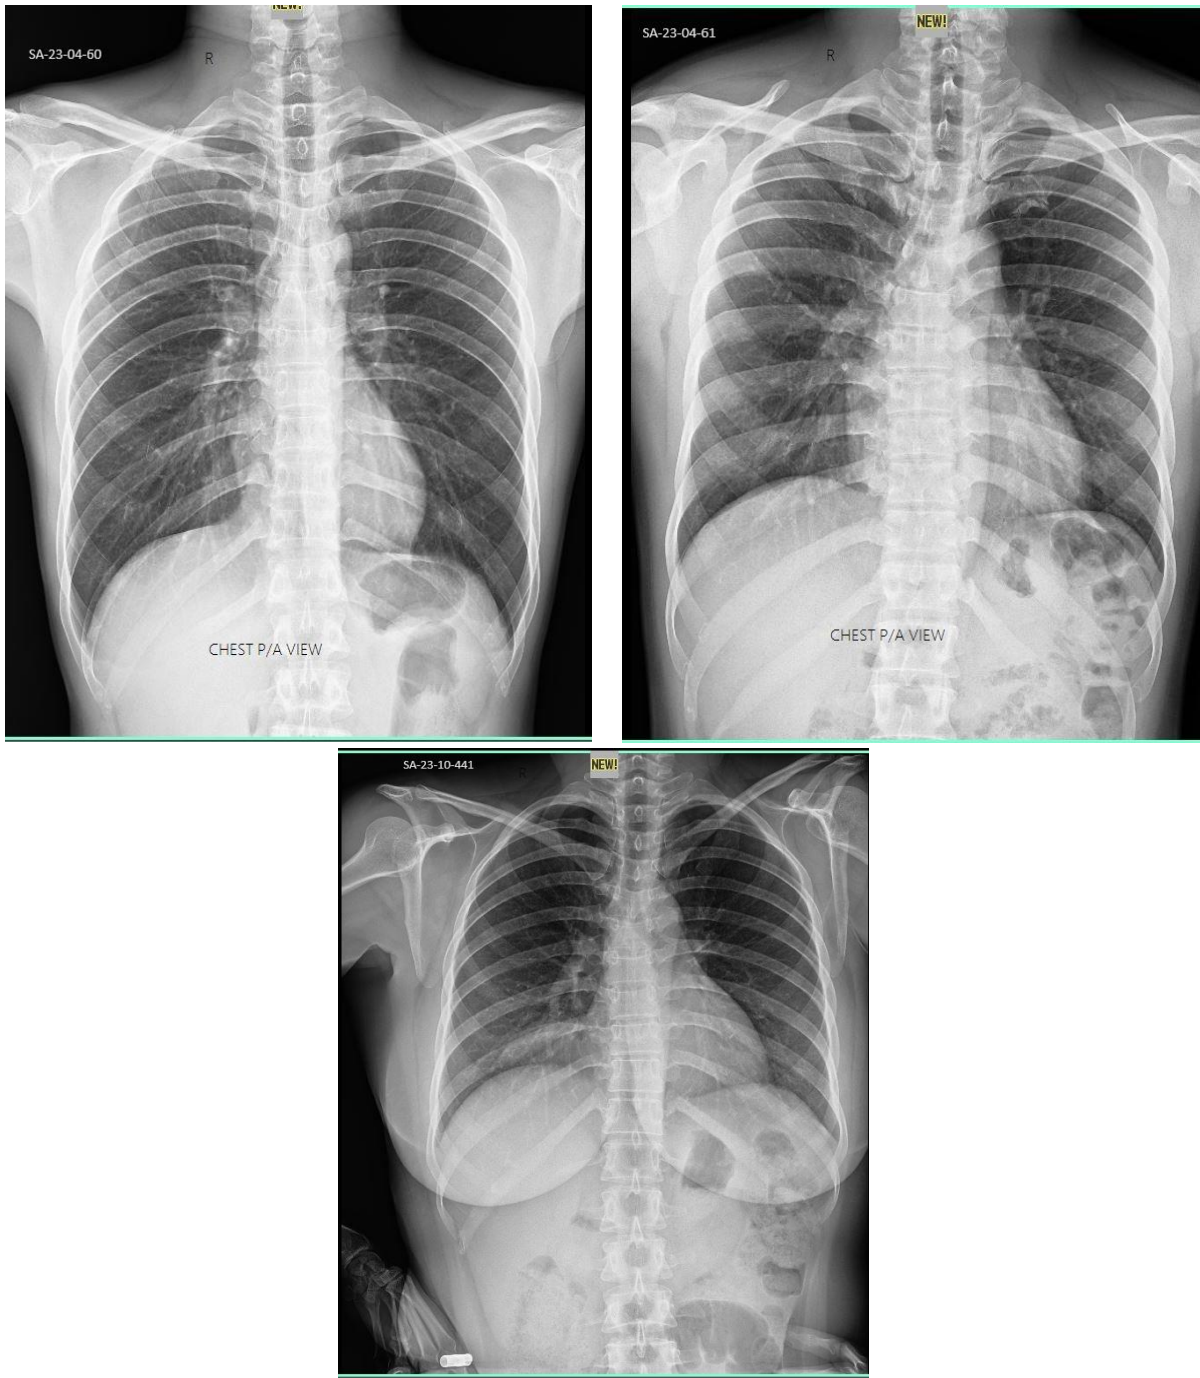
Chest P/A view X-Ray report of HCV positive patients
